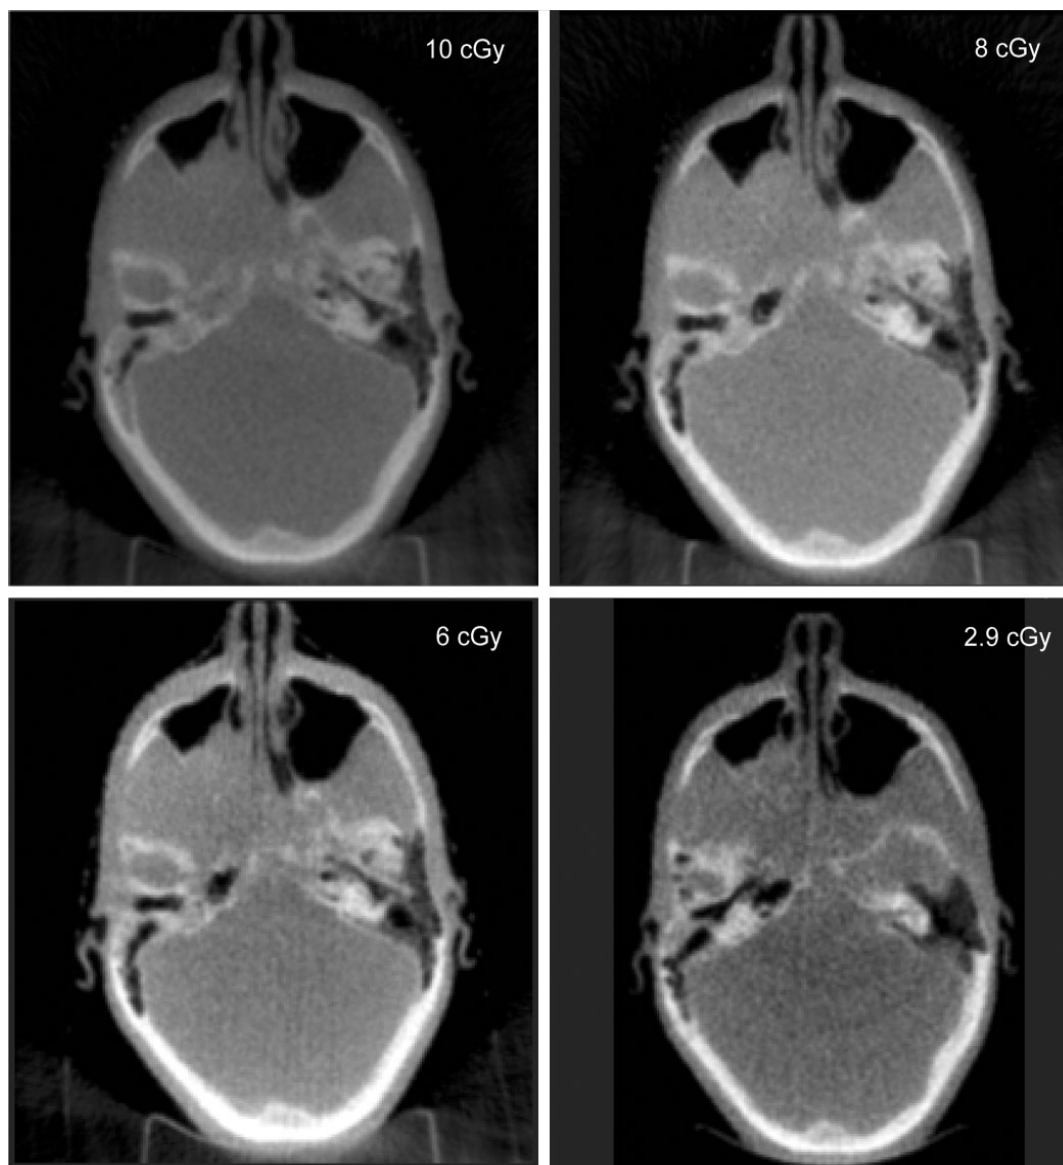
Examples of megavoltage cone beam CT (MV CBCT) images at different exposure levels, from 2.9 cGy to 10 cGy.
